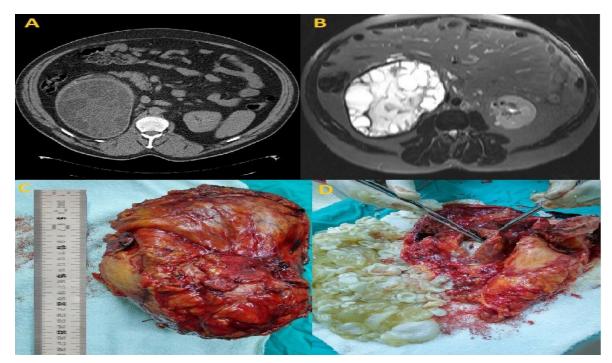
Renal Hydatid cyst different imaging methods and surgery material. A: Huge renal hydatid follicle cyst image CT image; B: Huge renal hydatid follicle cyst image MRI image; C-D: Nephrectomy material and macroscopic follicle image
